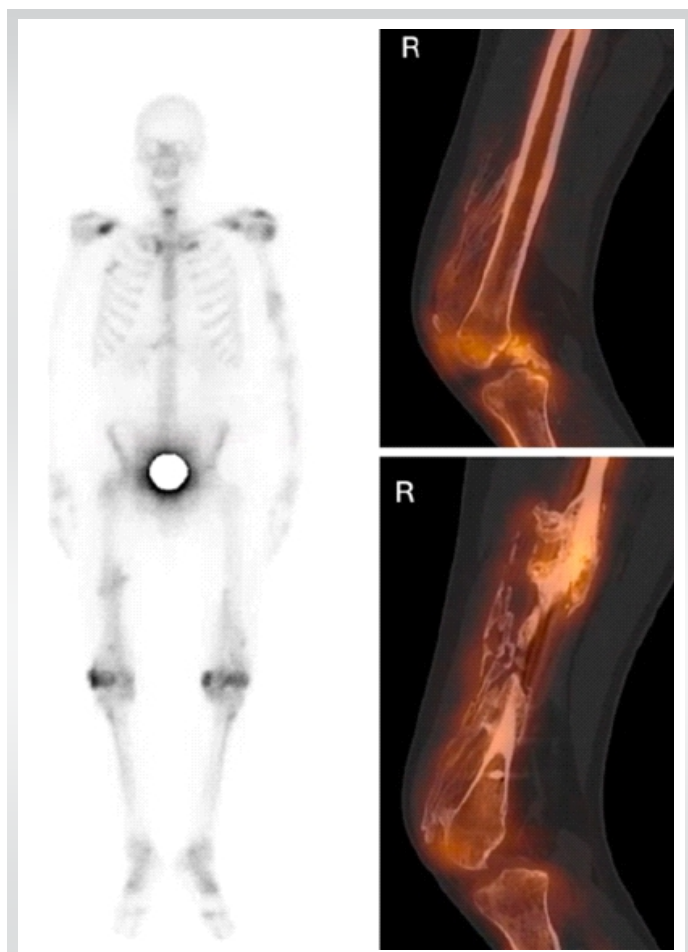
Single photon emission computed tomography (SPECT) at 8-month post-trauma demonstrating low-level tracer uptake indicating mature lesions. SPECT combined with computed tomography imaging performed 8 months after trauma. The images demonstrate low metabolic activity within the heterotopic ossifications, with only minimal residual tracer uptake in the distal anterior thigh region, consistent with mature and metabolically inactive lesions.
